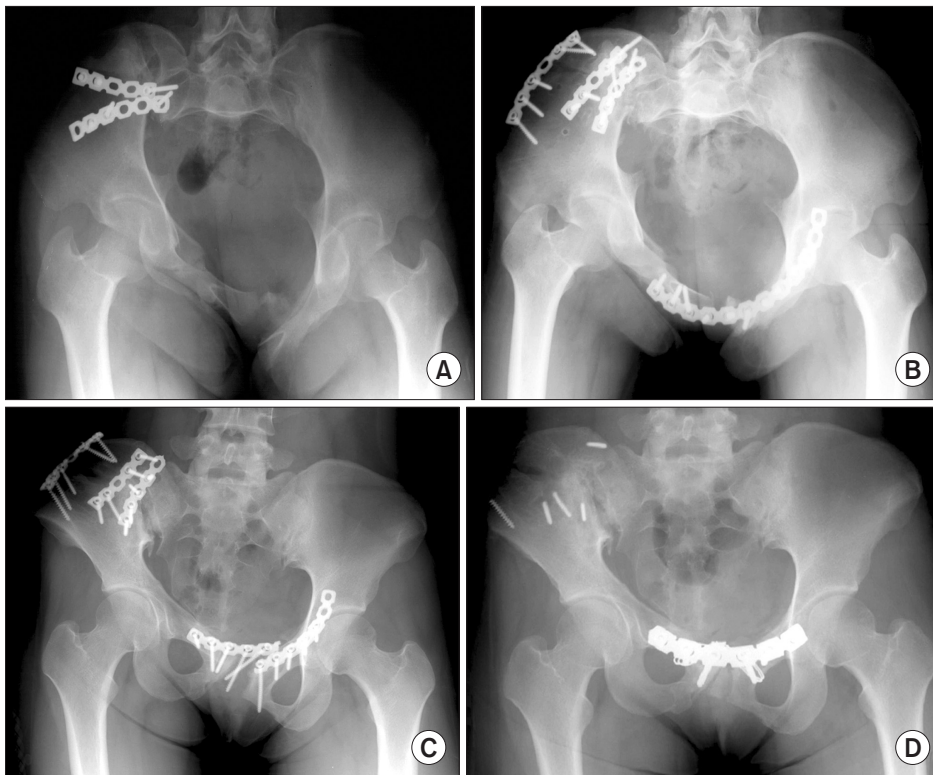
Case 3. (A) The initial inlet view radiograph shows severe residual internal rotation deformity of the right hemipelvis. (B) The radiograph obtained immediately after surgery shows correction of the internal rotation. (C) The radiograph obtained 2 months after surgery shows loss of reduction, metal failure, and nonunion. (D) In revision surgery, the anterior lesion was reopened and fixed with a broad plate.
